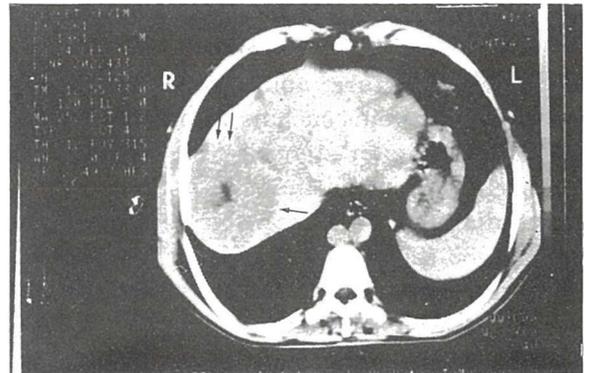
CT demonstrates the hypodense lesion in the right hepatic lobe (arrows)
